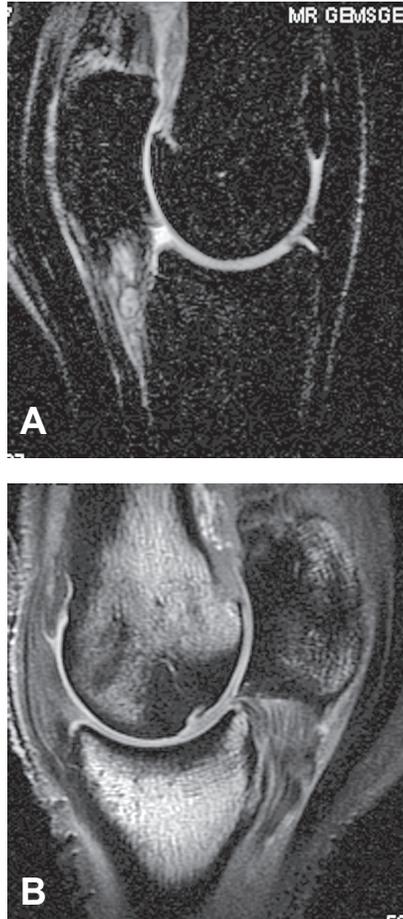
(A) MRI of tearing of the oblique distal sesamoidean ligament (STIR sequence). (B) MRI of bone edema and sclerosis with defect in distal metacarpus (T1-weighted spin echo sequence). Both images are from racehorses (courtesy of Dr. N. Werpy).
